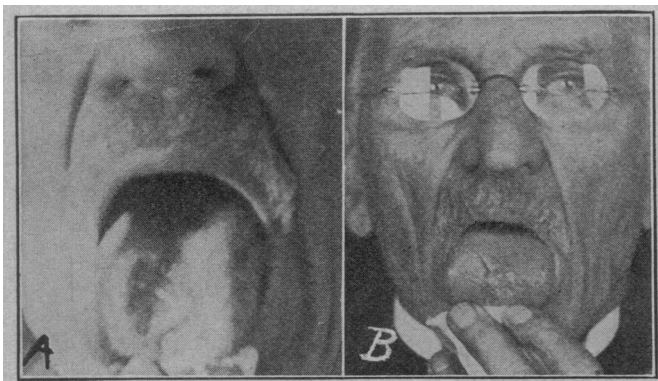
A, epithelioma of tongue of six months' duration in a man, aged 74, referred by Dr. J. C. Biddle of Fountain Springs, Pa. B, result of desiccation treatment under local anesthesia in May, 1911. There were enlarged glands on both sides of the neck in this case, which were probably inflammatory, since they disappeared after the treatment of the tongue lesion and the application of the roentgen ray to the neck. There was no recurrence in four and one-half years, when the patient died of some other disease.
